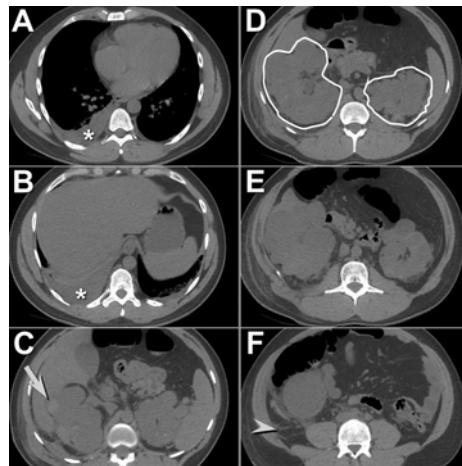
Unenhanced abdominal CT performed after development of acute renal failure following the percutaneous microwave ablation procedure shows cystic bilateral enlargement of both kidneys (shapes in D). Some of the cysts are hyperdense (arrow in C), consistent with hemorrhage or proteinaceous material. Mild perinephric fat stranding is present (arrowhead in F), which can be seen with retroperitoneal hemorrhage, but the mild nature of this finding is entirely consistent with the recent percutaneous microwave ablation procedure. Right pleural effusion (*) is again present.
